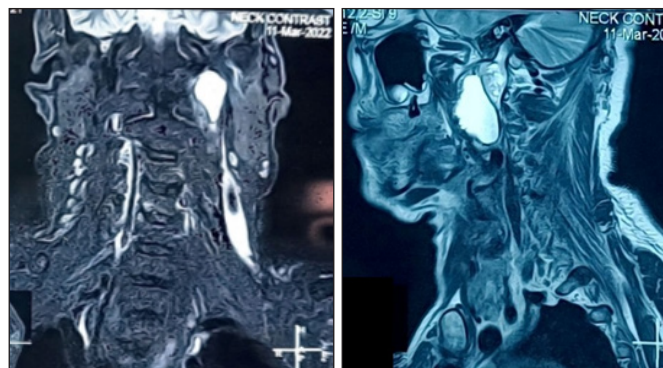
(A) MRI-Axial cut showing left vagal schwannoma
